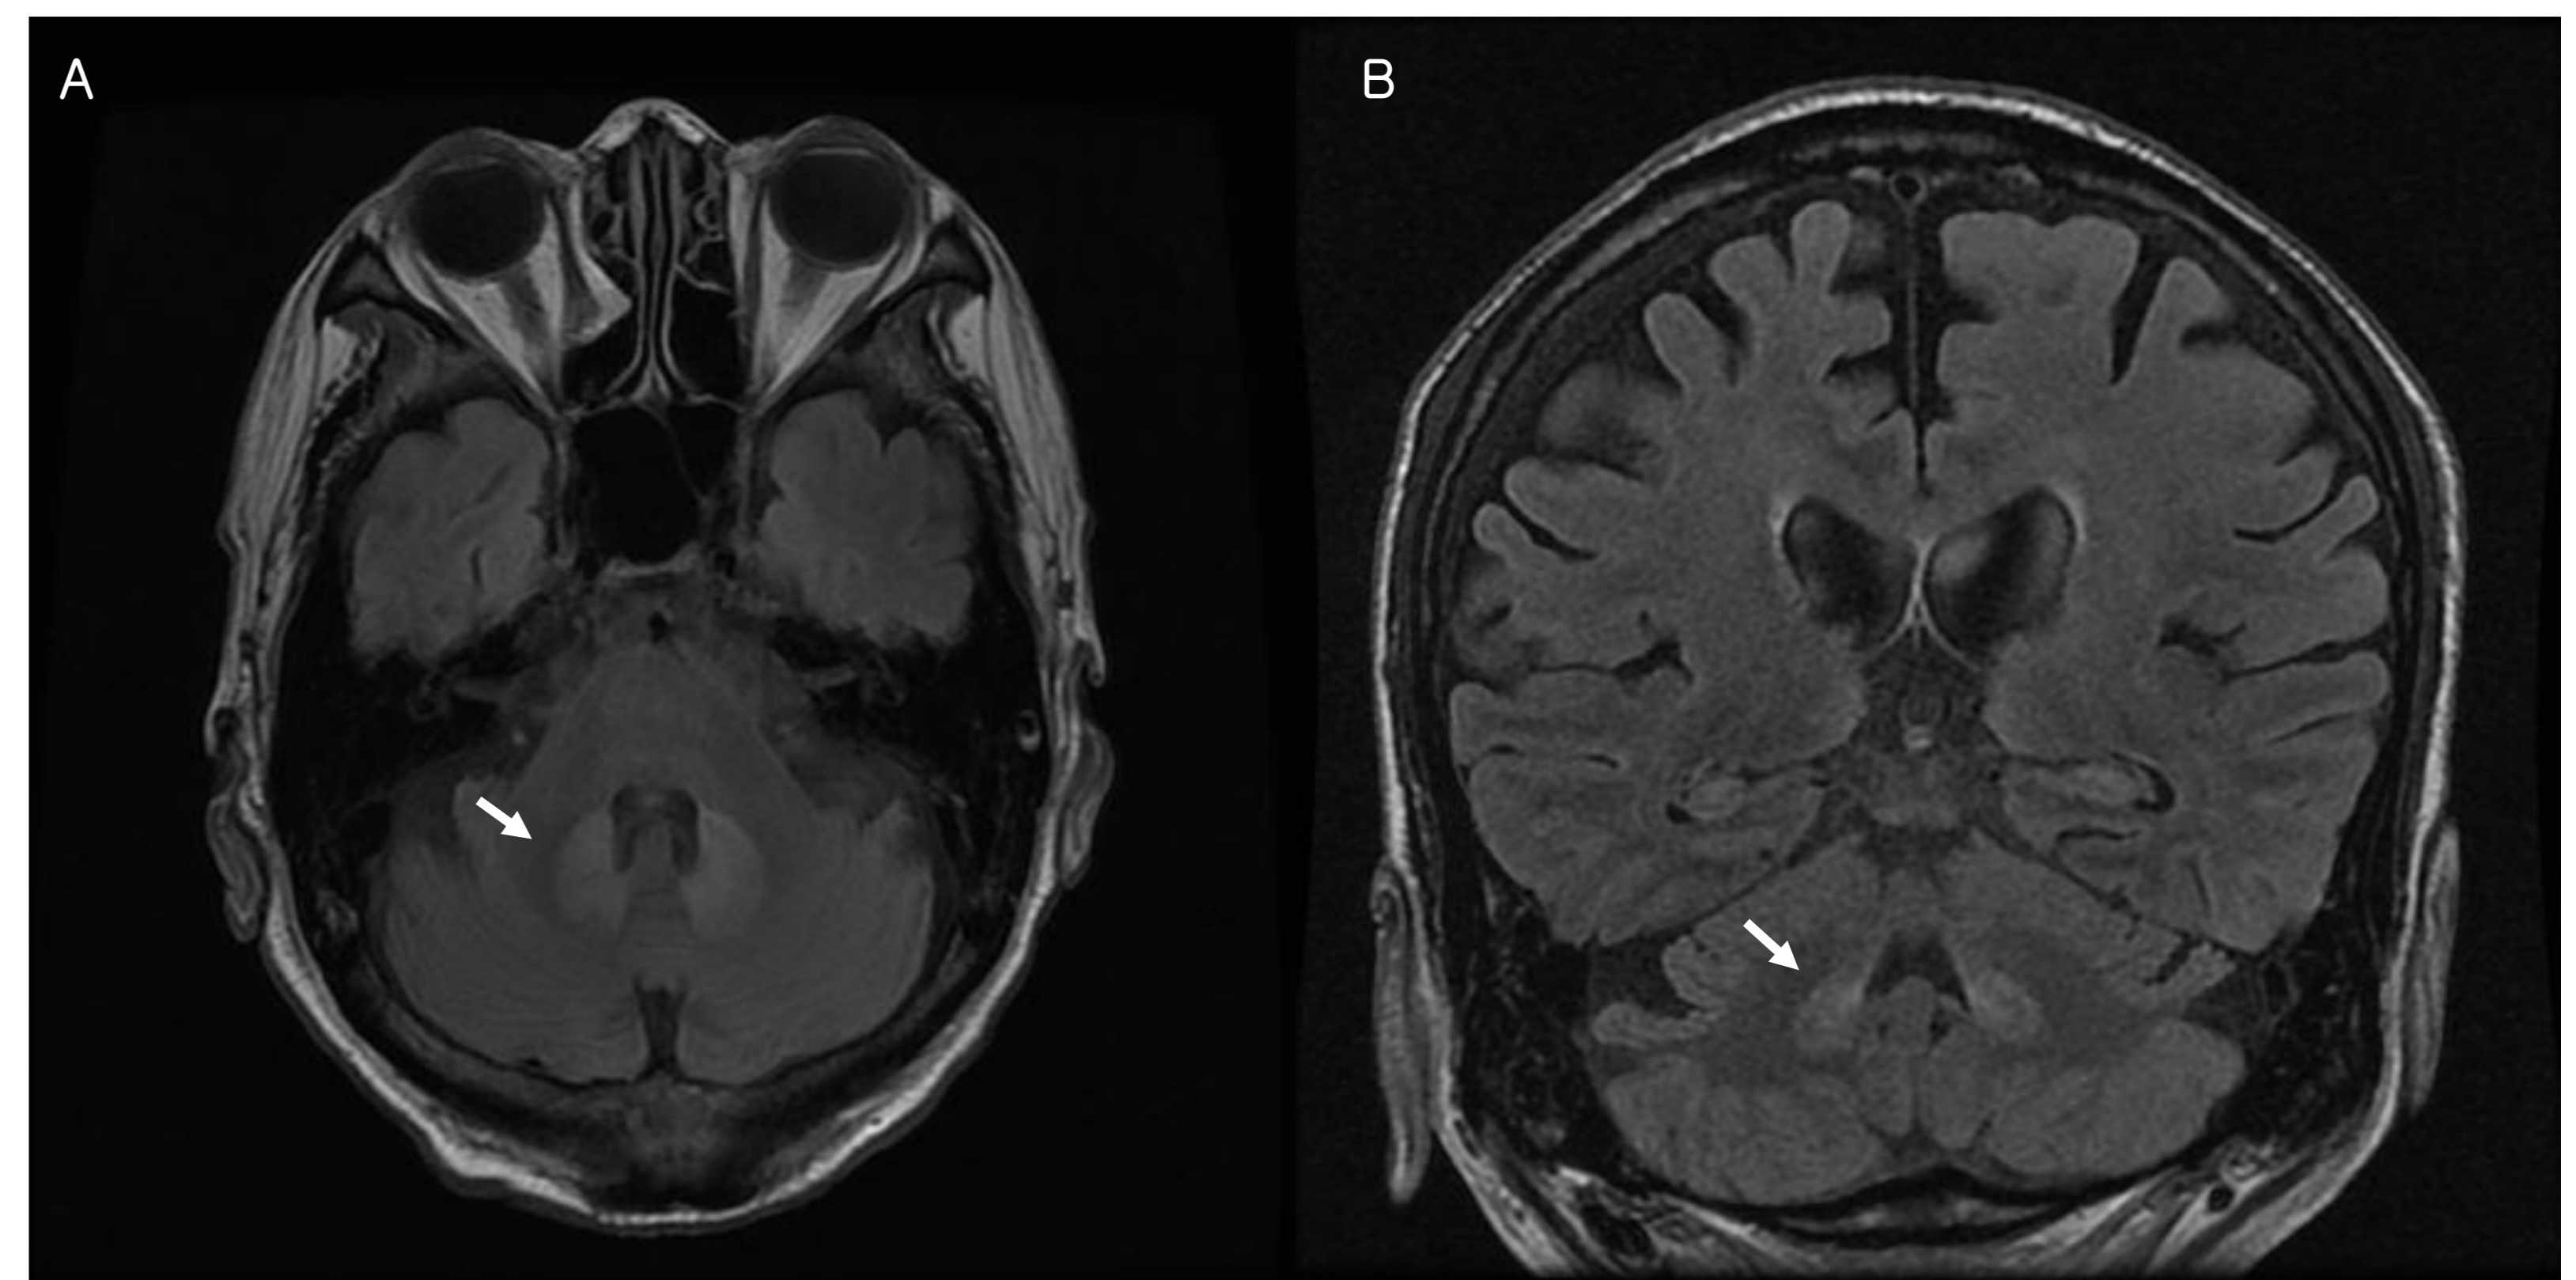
Fluid–attenuated inversion recovery (FLAIR) images, axial (A) and coronal (B), show bilateral symmetric hyperintense lesions in the cerebellar dentate nuclei (arrows).
